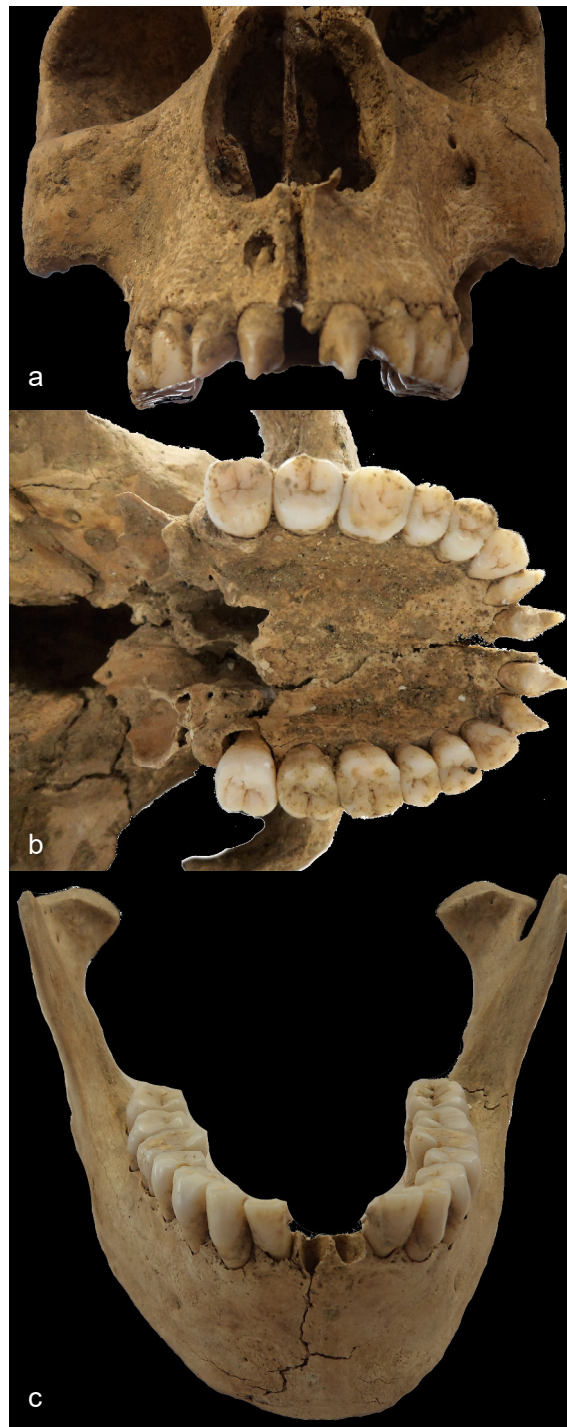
a) Frontal view of the skull and upper dentition. Note the periapical lesion in the buccal plate of the alveolar process at the apex of the root of the right upper central incisor; b) Lower view of the skull and upper dentition. Both central and lateral incisors
